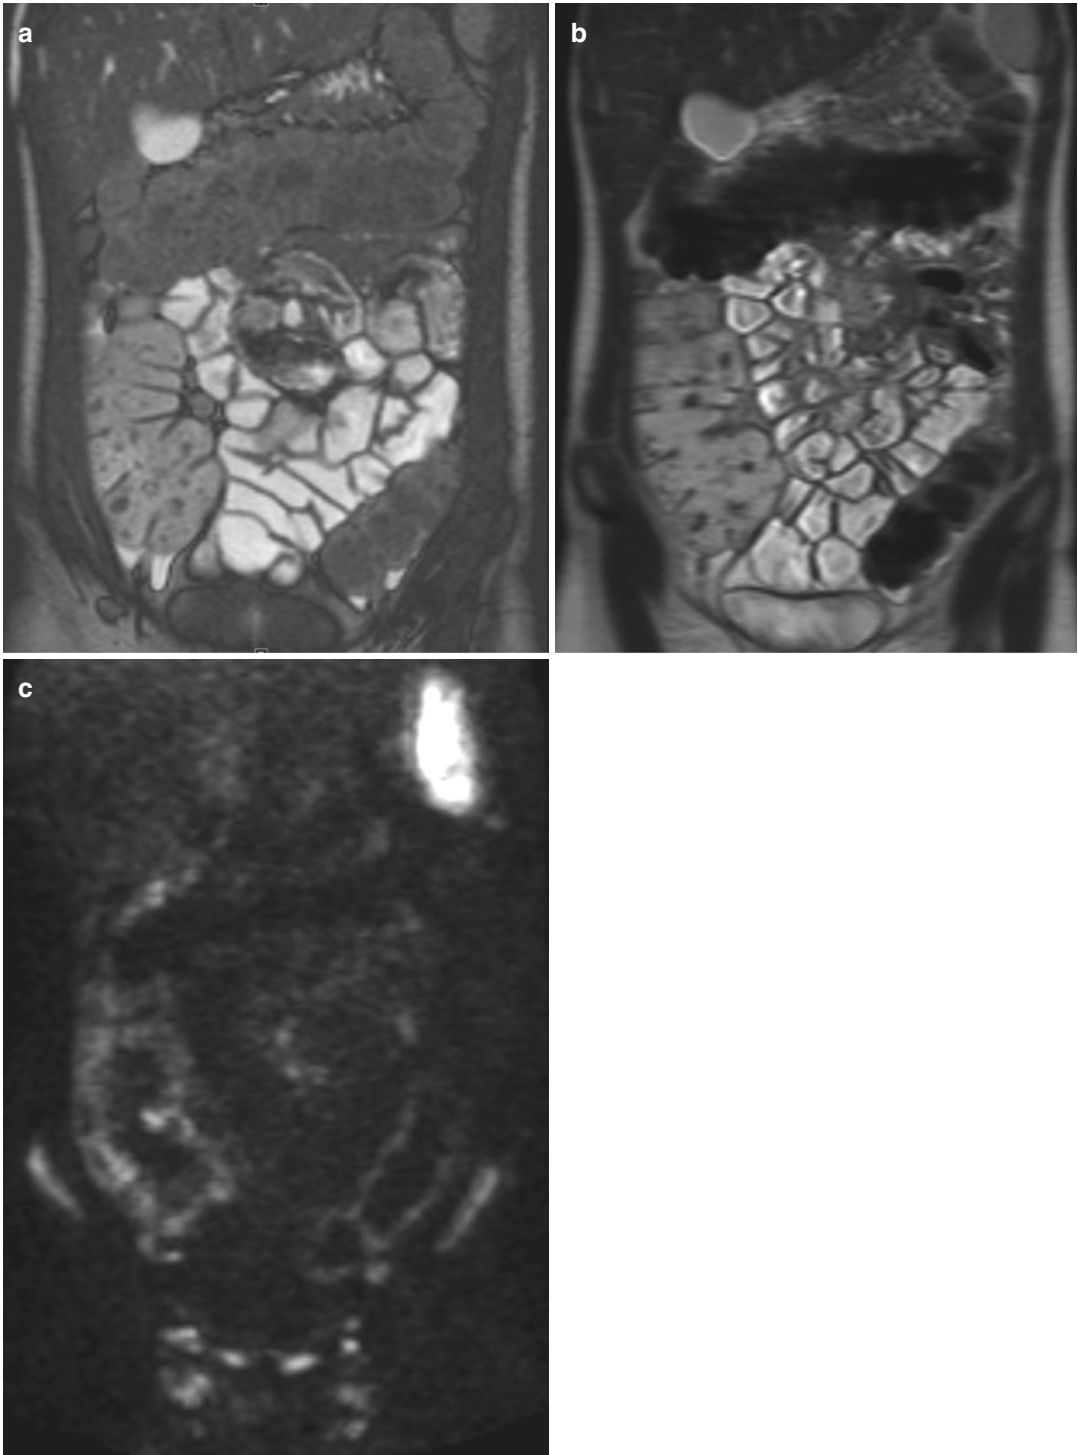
Eleven-year-old girl who presents a light pancolitis on endoscopy (UC). (a) Coronal balanced turbo field echo (bTFE) sequence reveals a discrete thickening of the left colon with no evidence of thickening of the cecum. (b) Coronal T2-weighted turbo spin-echo (bTSE) sequence
